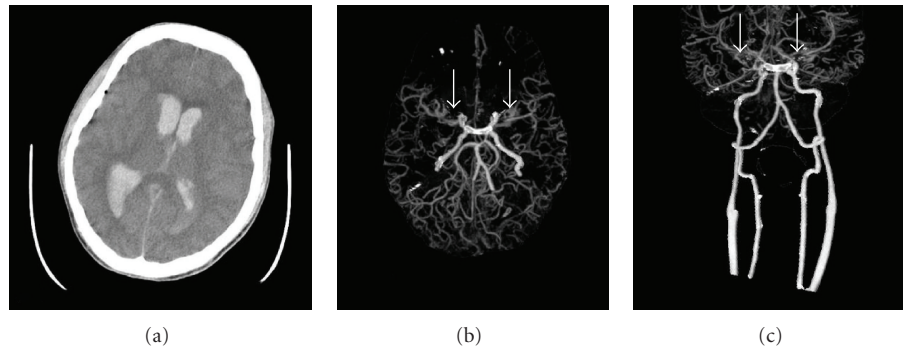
A 17-year-old boy was presented with sudden loss of consciousness and generalized seizure attack. Nonenhanced CT study (a) showed acute intraventricular hemorrhage. CT angiography (b, c) disclosed occlusion of bilateral prebifurcation M1 segment of middle cerebral arteries with some moyamoya vessels (arrows).
